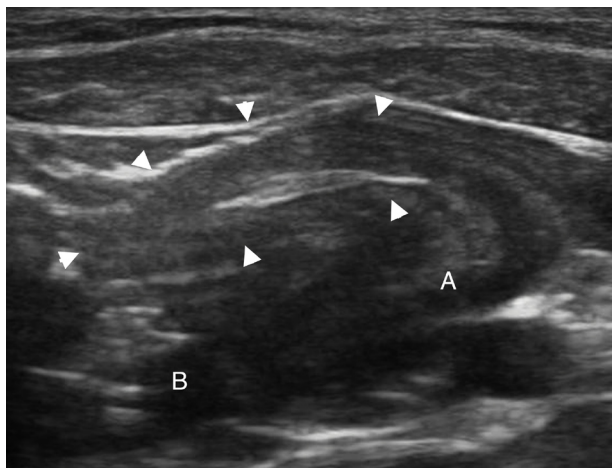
Oblique ultrasonographic view of the cervix. A hyperechoic grass awn located in the vaginal fornix (arrowheads) is visible. The grass awn appears as having a cranially oblique direction. The cranial oblique aspect of the vagina is on the left of image. Linear transducer (15 MHz); A = cervix; B = uterus
